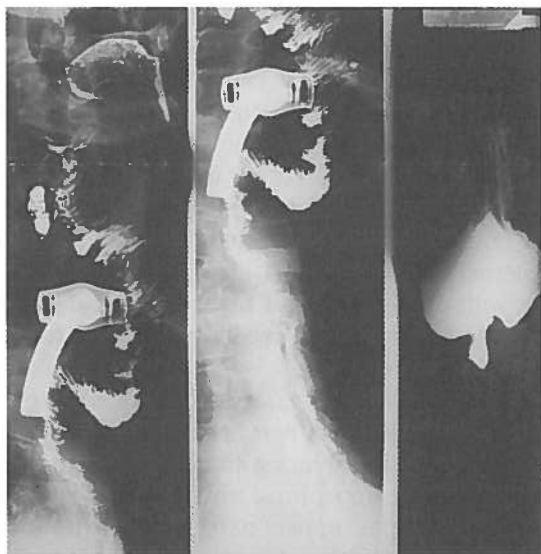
The X-ray controlled swallow shows a free passage of the graft from the oral base to the stomach without extravasation.
